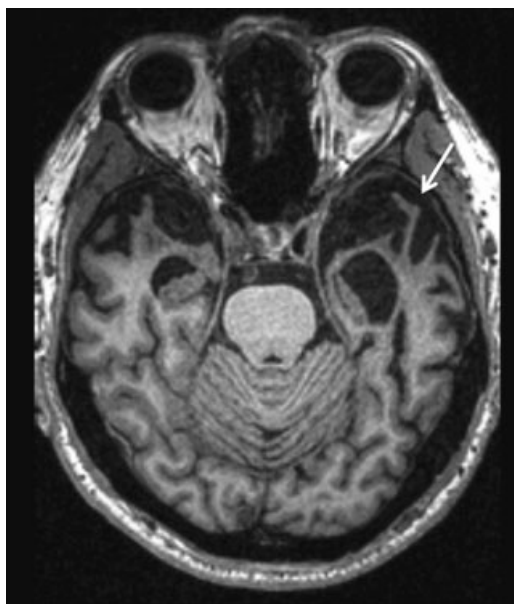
T1-weighted magnetic resonance imaging in a 63-year-old patient with semantic variant primary progressive aphasia, showing profound left (noted by an arrow) greater than right anterior temporal lobe atrophy. Orientation is radiological.
